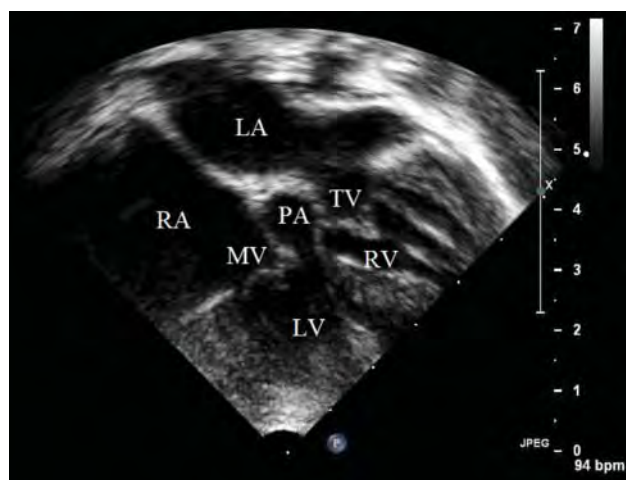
Subcostal coronal echocardiography view at the level of the atrioventricular valves. The pulmonary artery, lacking a subpulmonary conus, is wedged between the atrioventricular valves, in this case leading to subpulmonary stenosis. Mitral–pulmonic fibrous continuity is present. LA, left atrium; LV, left ventricle; MV, mitral valve; PA, pulmonary artery; RA, right atrium; RV, right ventricle; TV, tricuspid valve.
